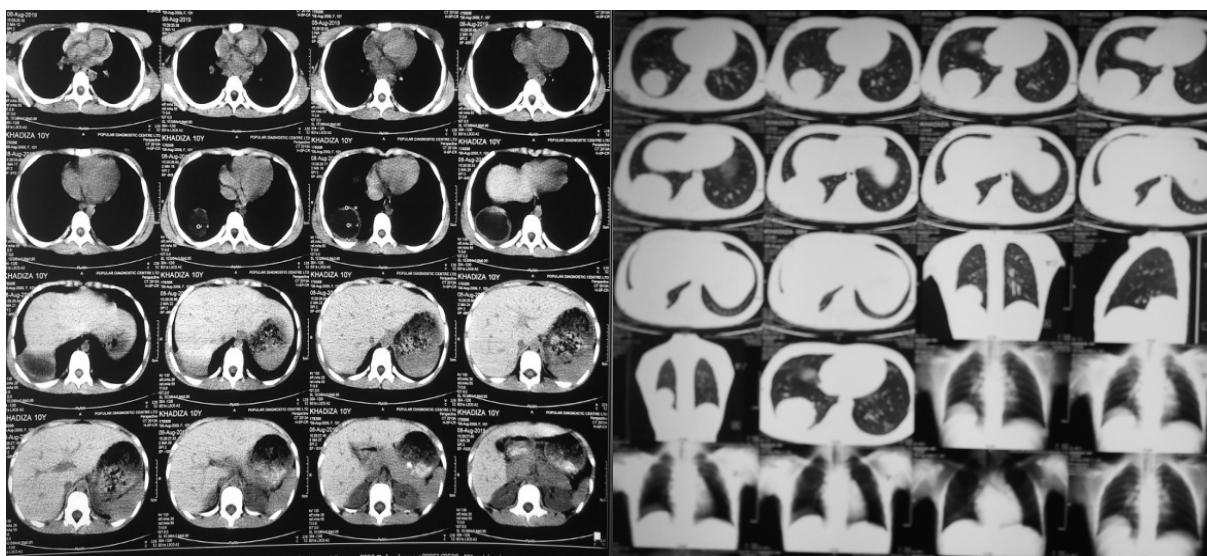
HRCT of Chest with contrast revealed a well defined cystic lesion measuring about 5.27×4.37 cm within posterior basal segment of lower lobe of right lung, rest of the parenchyma appears normal. Post contrast scan revealed no abnormal enhancement. The visualized parts of abdominal organs appear normal.
